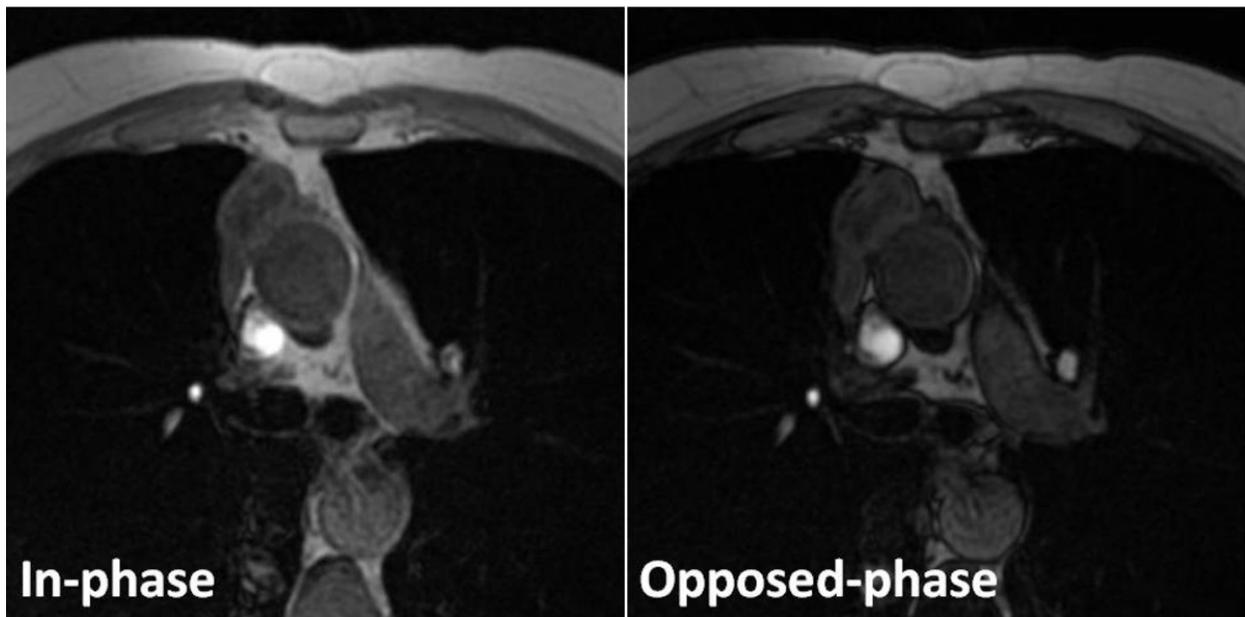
Thymoma in a 52-year-old men with myasthenia gravis. Transverse in-phase (155/4.6) and opposed-phase (155/2.1) gradient-echo T1-weighted MR images demonstrate no change in signal intensity of the lesion on the opposed-phase image relative to the in-phase image. The CSR is 1.050.
